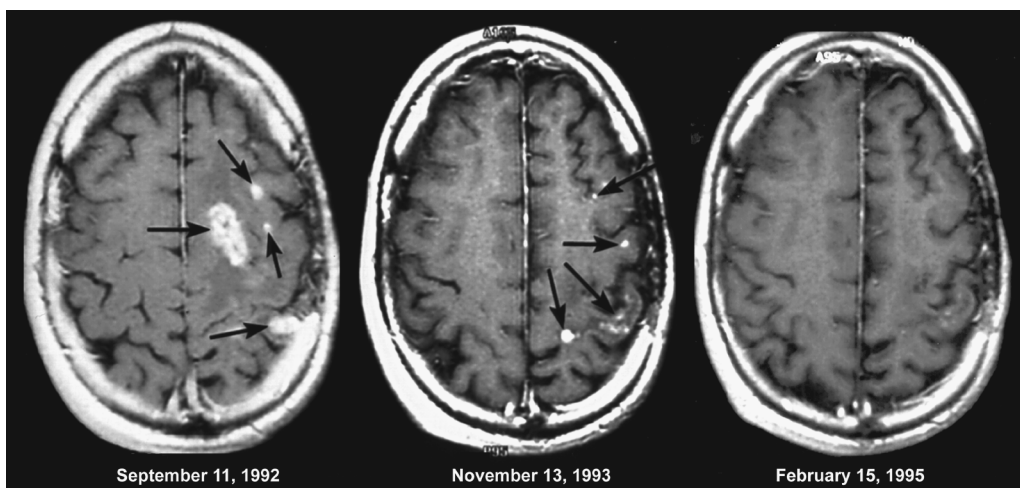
Post-contrast axial T₁-weighted MR images of the brain show spontaneous regression of radiation-induced enhancing lesions (arrows) within lesions in the left frontoparietal lobe. The patient is status postsurgery with accelerated radiation therapy and chemotherapy for a nonenhancing anaplastic astrocytoma involving the parietal lobe.
